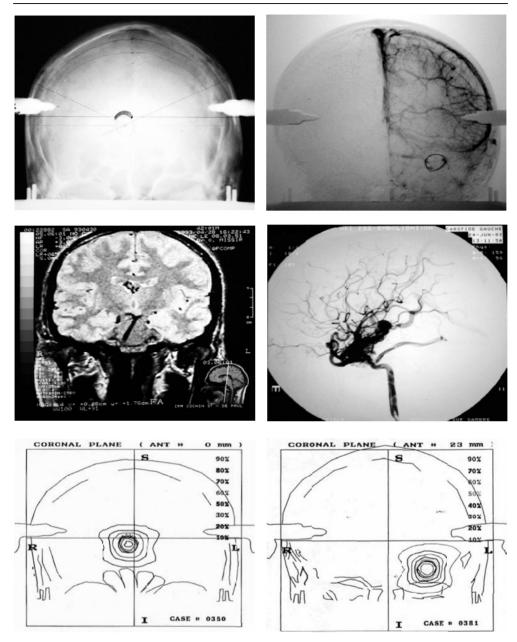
In SRT, treatment planning is strongly dependent on the imaging modalities that are available. In the two panels the coronal images of two AVM patients are shown. The upper coronal images are a classical angiography used for target localization and a subtracted conventional angiography for target delineation. The MRI image (middle left) represents an imaging modality that is used for better target (nidus) visualization. The use of the corresponding DSA image (middle right) also aims at a better target visualization. Finally, the lower two graphs are the corresponding reconstructed coronal images from the TPS at the level of isocentre with the isodose distribution being also demonstrated. The order with which the images are arranged represents the information and process flow in treatment planning.
